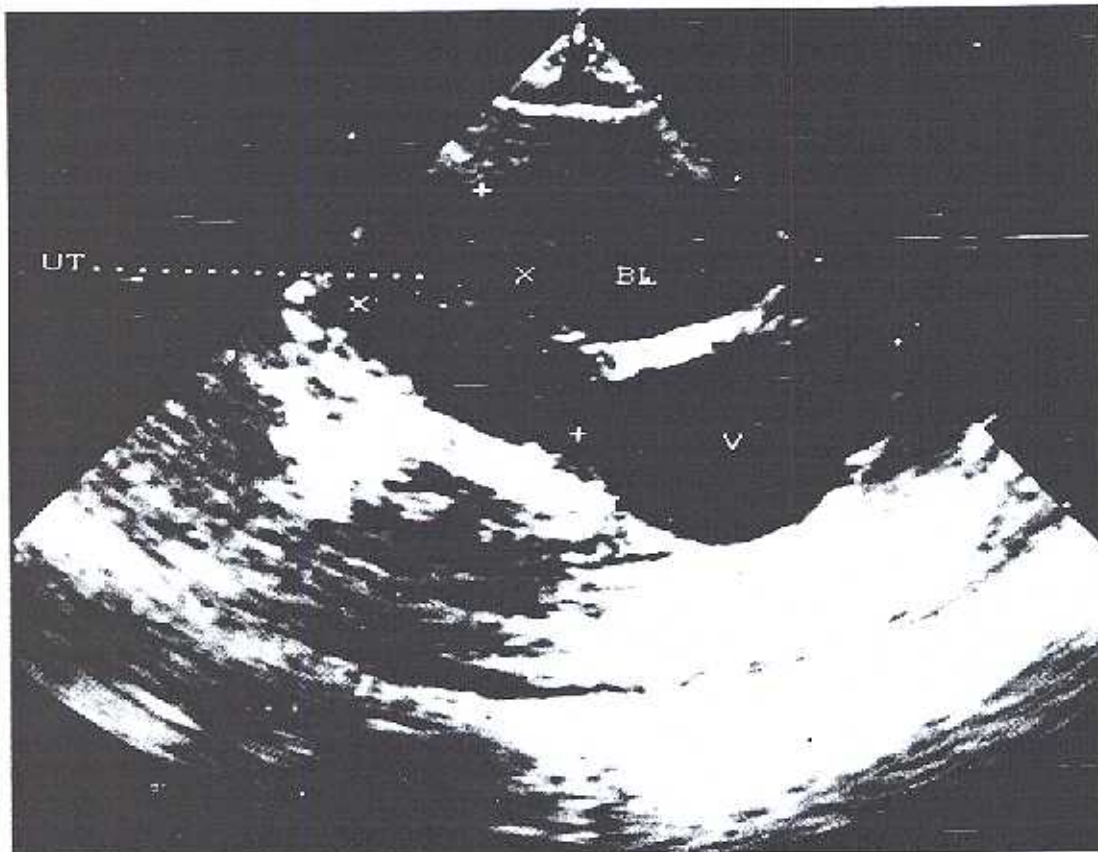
Ultrasound (sagittal) of pelvis showing anteriorly bladder (BL), postero-superiorly uterus (UT), and postero-inferiorly vagina (V).
